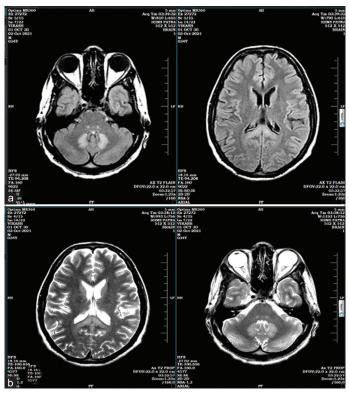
(a) T2 FLAIR magnetic resonance imaging (MRI) and (b) T2W MRI at the level of middle cerebellar peduncle and septum pellucidum show hyperintense signal change in dentate nucleus of cerebellum, two small foci in dorsal pons and splenium of corpus callosum, respectively, suggestive of interstitial edema as no restriction in diffusion-weighted images and apparent diffusion coefficient sequences
